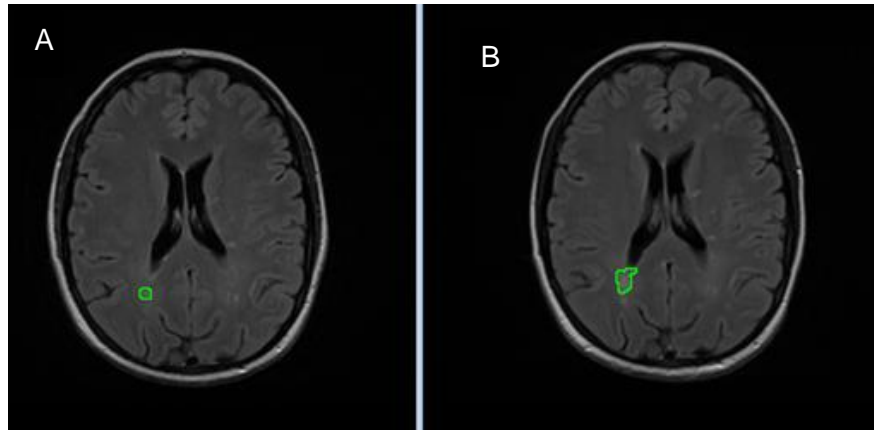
(A) Demonstration of enlarging T2 lesion (ROI) on initial FLAIR image (B) Demonstration of enlarging T2 lesion (ROI) on final FLAIR image
